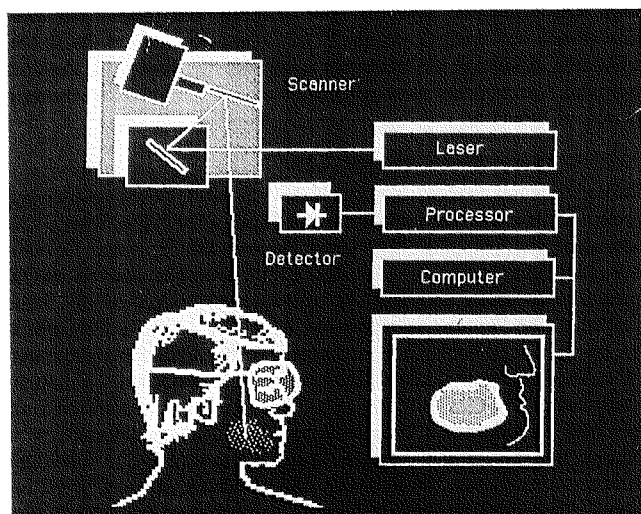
The principles of laser Doppler perfusion imaging.
